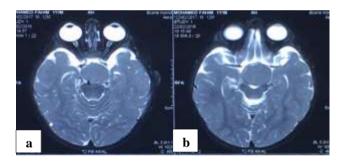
(a and b): MRI brain of the patient showing suprasellar mass.
